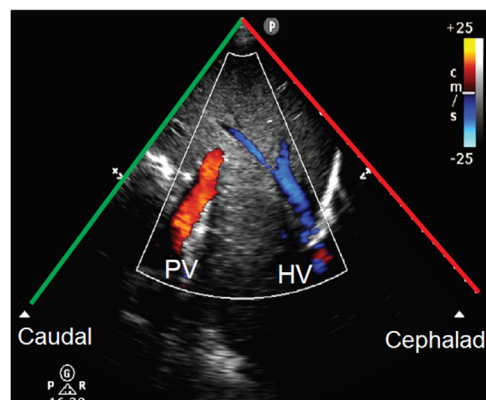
Transthoracic ultrasound with color Doppler showing the relative position the portal vein (PV) and hepatic vein (HV).
